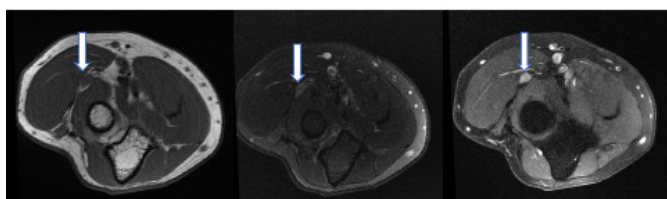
The lesion is isointense on T1-weighted MRI
